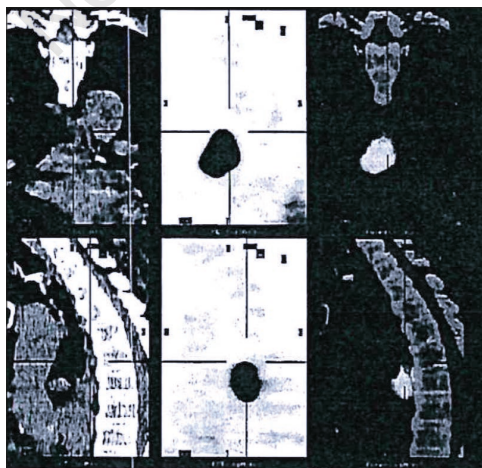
Positron emission tomography-computed tomographic scan showing high turn-over subcarinal lymphadenopathy.
